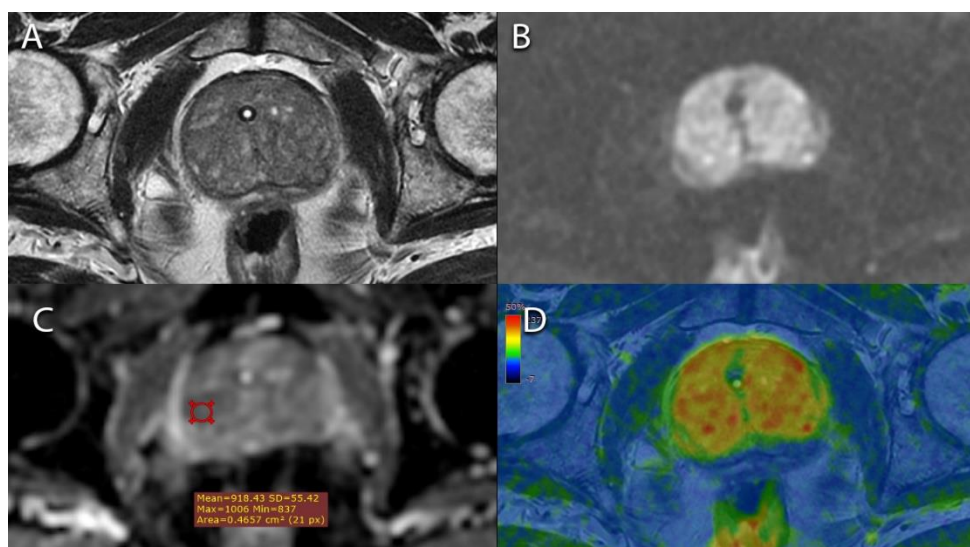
MRI of the prostate, axial images. A: T2-WW FRFSE; B: diffusion-weighted image (DWI), the areas of greatest restriction of diffusion have the brightest representation; C: ADC-map, ROI (red circle) is located above the zone of the greatest hypointensity of the MR signal, the ADC is $0.92 \times 10^{-3} \text{ mm}^2 / \text{s}$; D: fusion map T2-WW and DWI, red color corresponds to the area of the greatest restriction of diffusion.
